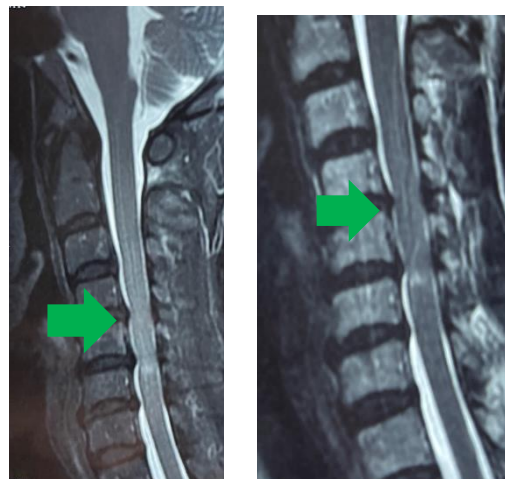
Initial MRI showed multiple disc herniation with significant oedema in spinal cord (arrow) at level C5-6
